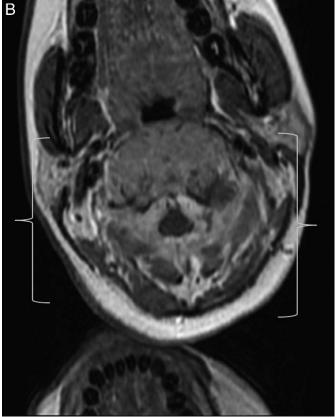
(A) Sagittal T2W1 magnetic resonance imaging revealed a mass replacing most of the C2 vertebral body. There was involvement of the odontoid and ventral epidural space from C2–C5. (B) Axial T1W1 magnetic resonance image shows circumferential tumor at C2 compressing the spinal cord.
